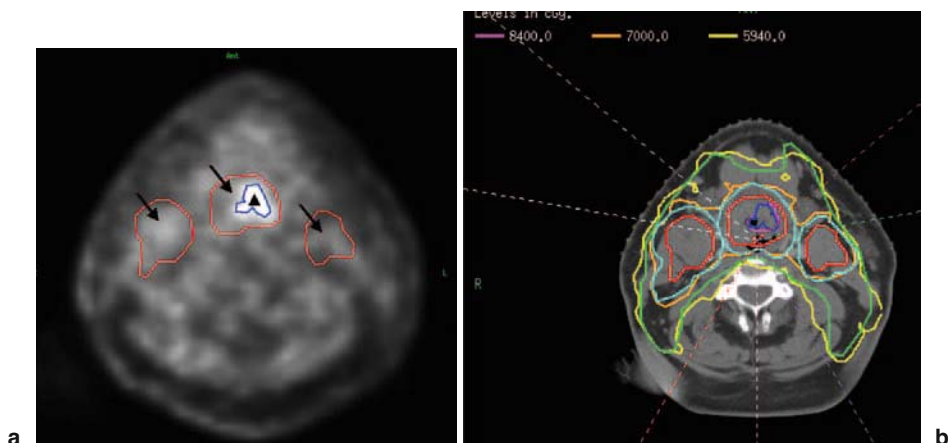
a Axial image from an ^{18}F -misonidazole (FMISO) scan of a supraglottic carcinoma showing a small hypoxic region in the middle of the tumor (*arrowhead*). The *arrows* point to areas of the tumor and involved nodes that were avid on fluorine-18-2-fluoro-2 deoxyglucose (FDG) positron emission tomography (PET). The *red lines* delineate the gross tumor volume based on FDG-PET and computed tomography (CT), the *turquoise lines* denote the planning target volume prescribed to 70 Gy, and the *dark blue line* delineates the hypoxic region inside the tumor. b An example of an FMISO PET-guided intensity-modulated radiotherapy (IMRT) plan for the same patient. Note the 84-Gy isodose line (*in magenta*) covers the hypoxic region. The *orange line* represents the 70-Gy isodose line
